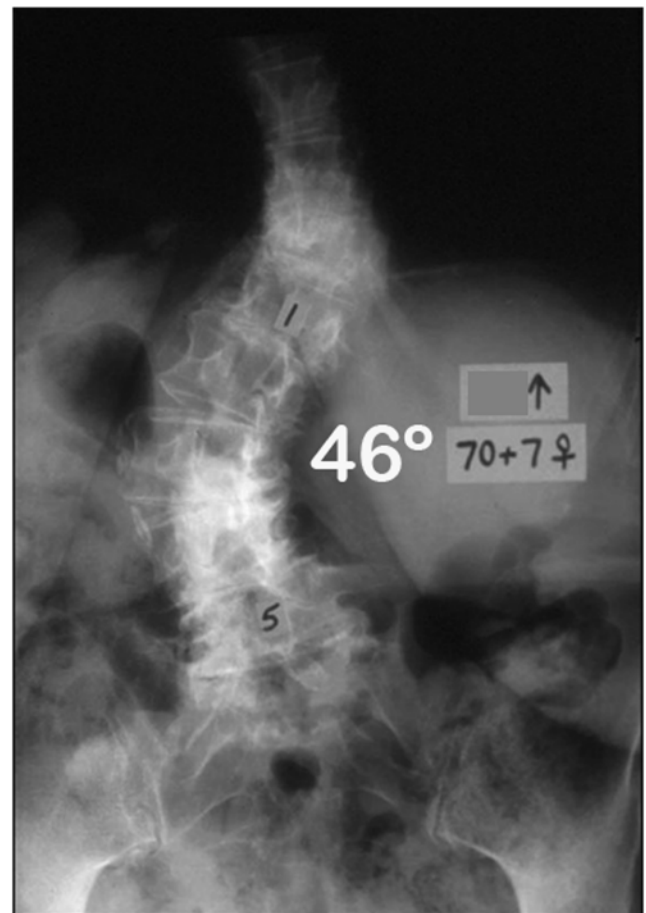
Radiograph demonstrating features of fractional degenerative lumbar scoliosis.
